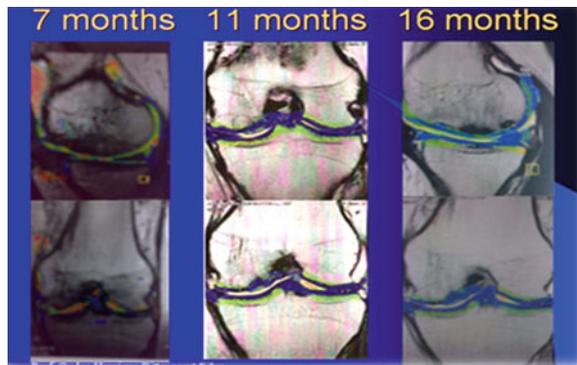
Coloured magnetic resonance imaging
